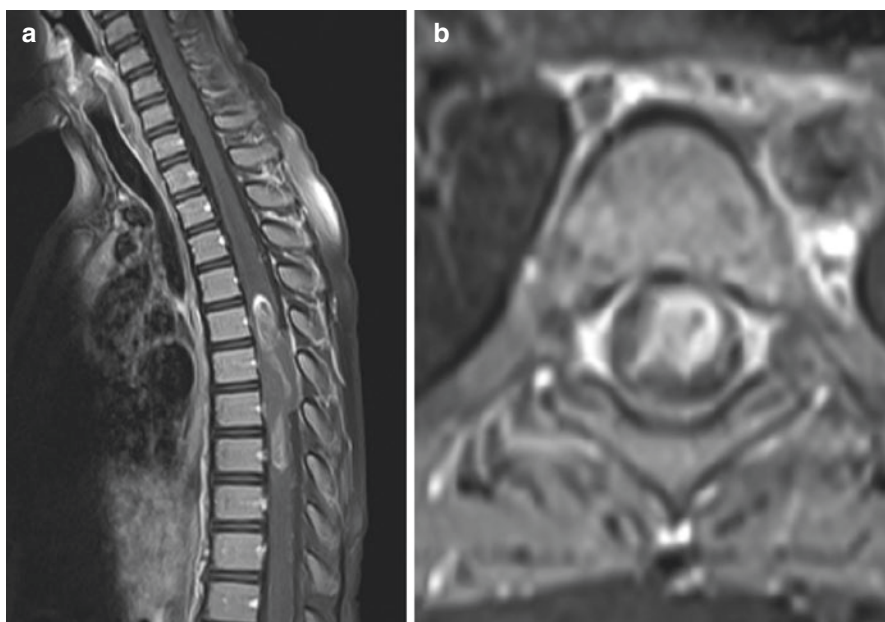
Spinal cord glioblastoma. Sagittal (a) and axial (b) of views thoracic MRI showing spinal cord glioblastoma with non-homogenous enhancement, swelling of the cord and adjacent syrinx
